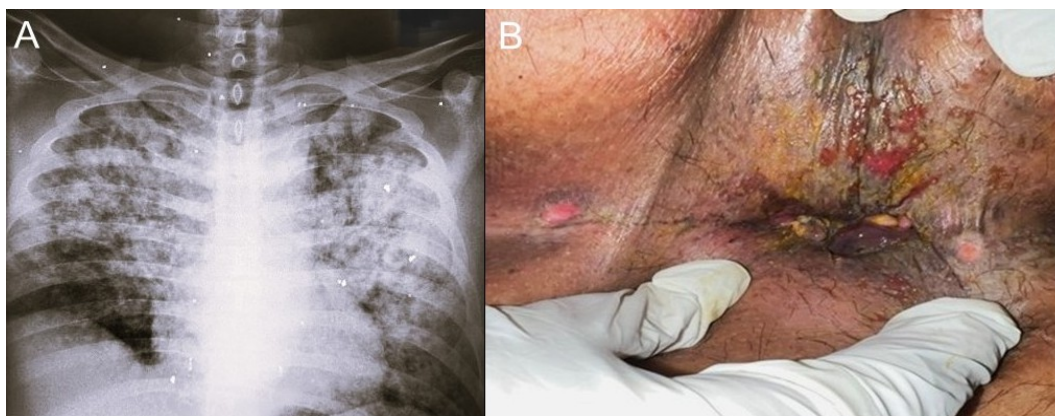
Anal tuberculosis with concomitant active pulmonary tuberculosis in an HIV-positive patient. A. Chest radiograph showing bilateral patchy opacities predominantly in the upper lung fields, consistent with pulmonary tuberculosis. B. Perianal region showing multiple fistulous openings and superficial ulcerations. Xpert MTB/RIF assay of perianal discharge was positive for *Mycobacterium tuberculosis*.
